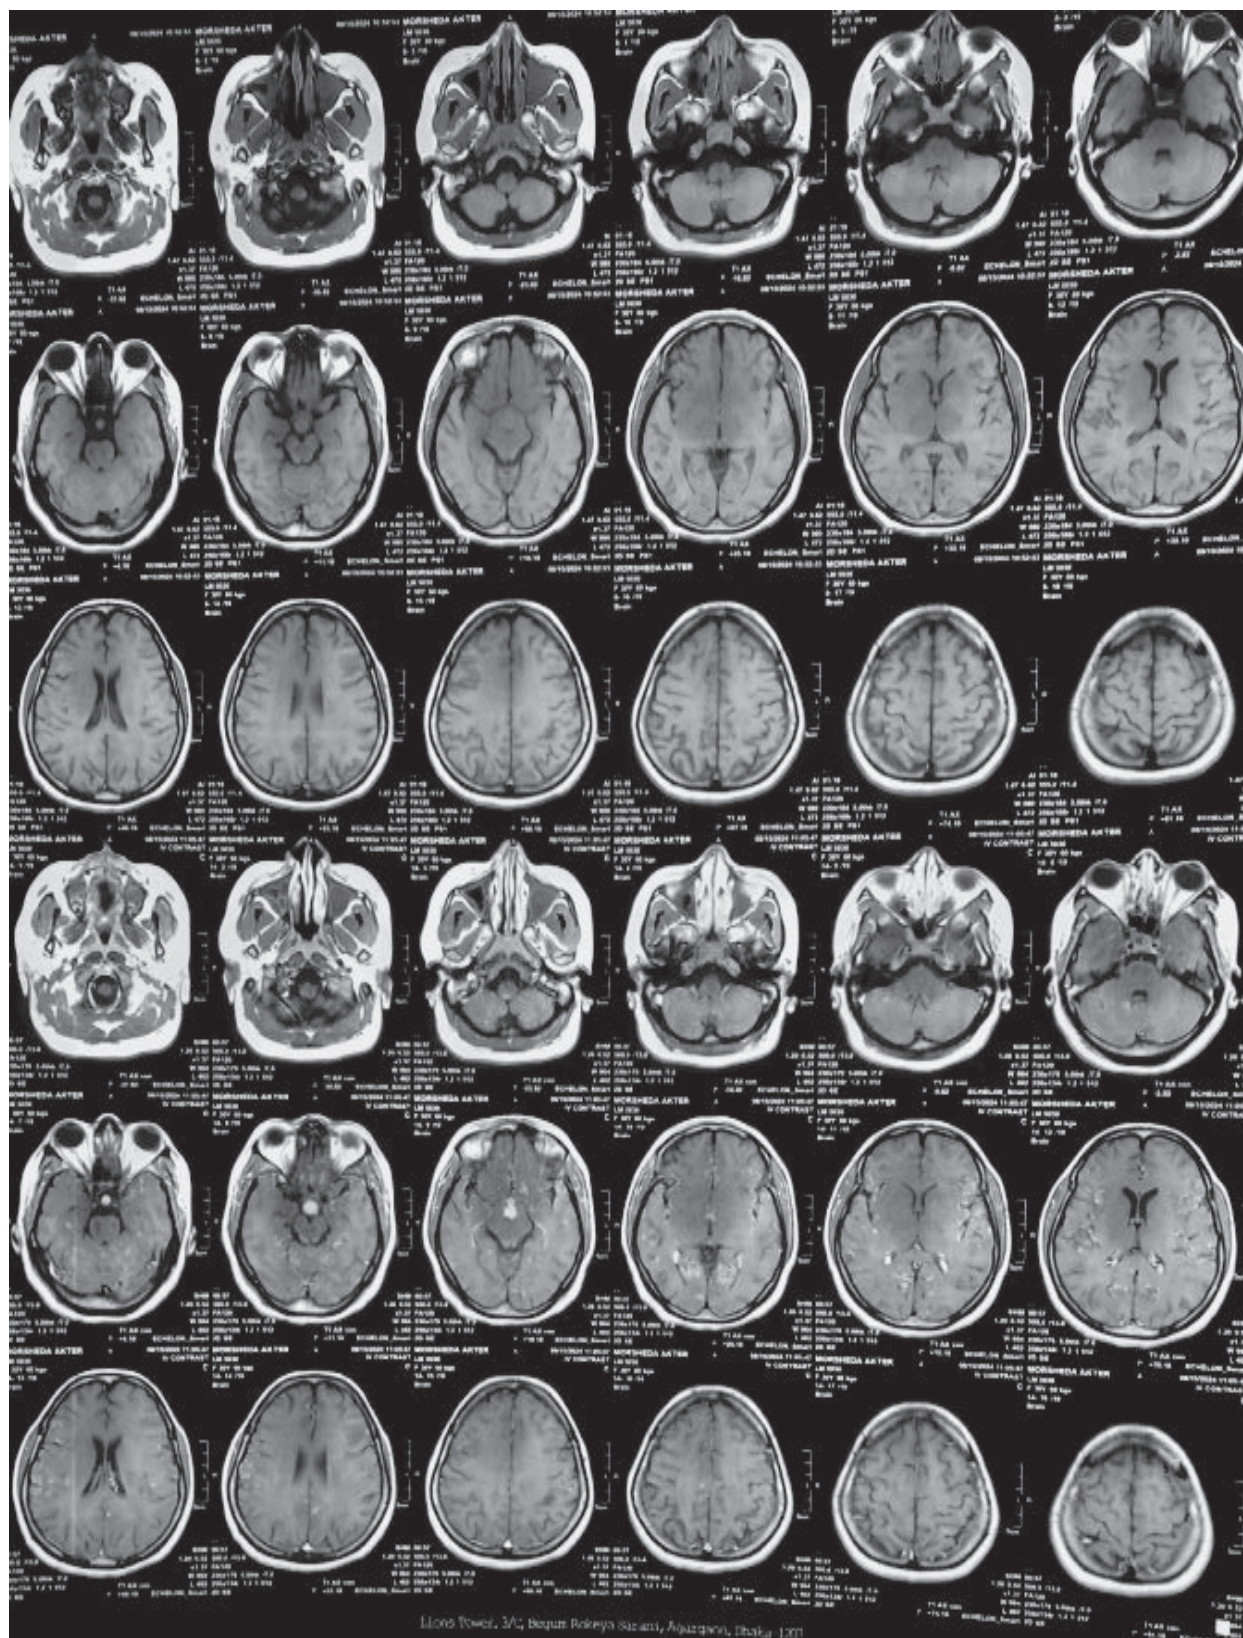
MRI of brain multiple axial cut T1 and T1 contrast sequence shows a contrast enhancing lesion in sellar and suprasellar region along with nodular leptomeningeal enhancement
